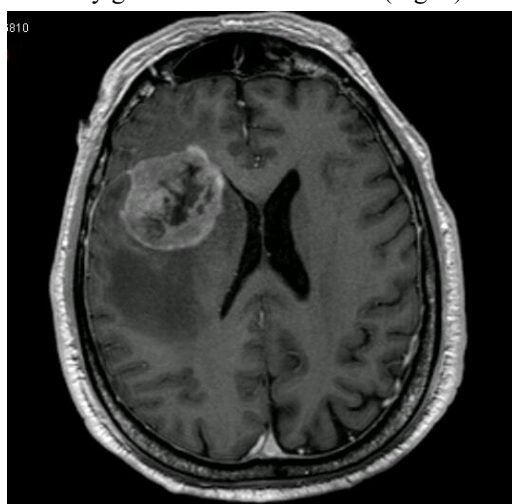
Magnetic Resonance Imaging (MRI) finding
